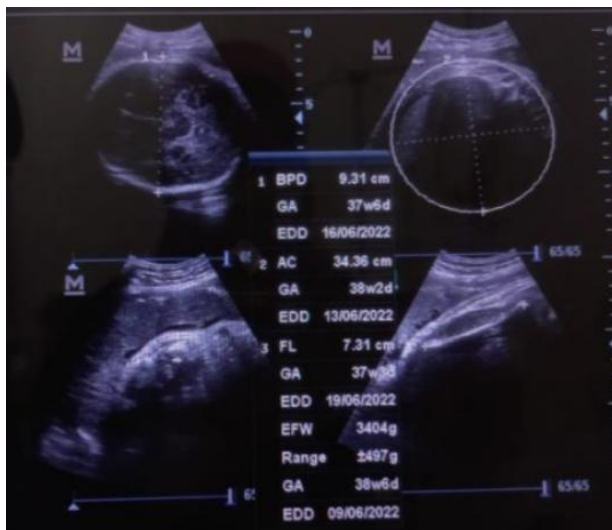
Normal Ultrasound Findings in Patients
